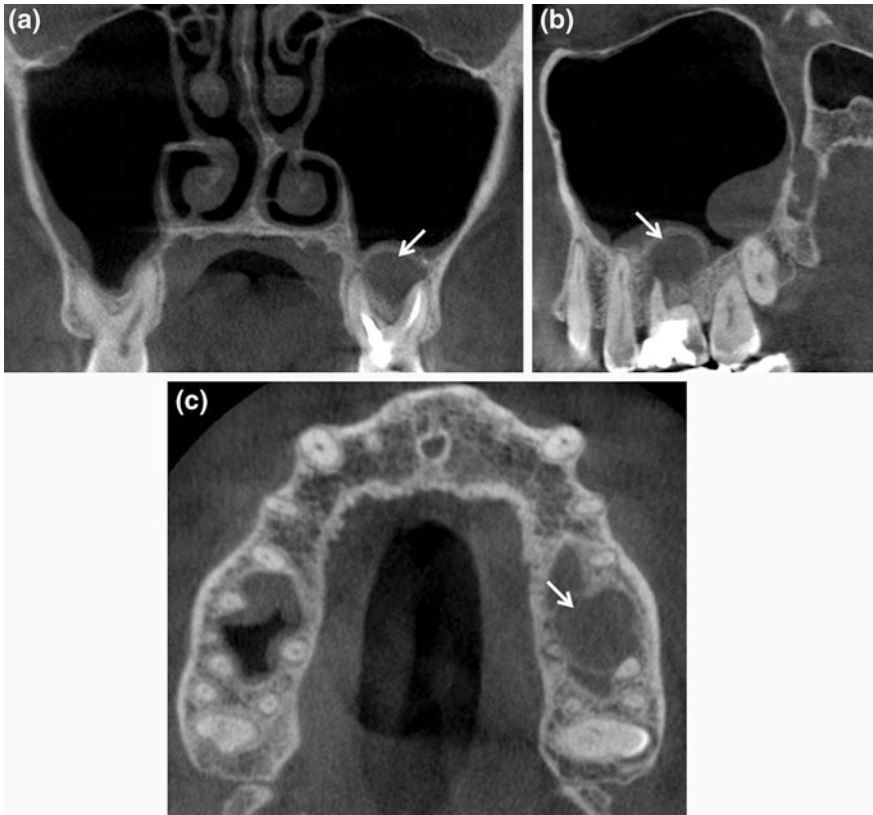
CBCT coronal (a), sagittal (b) and axial (c) scans demonstrating presence of odontogenic sinusitis in left paranasal sinus (*thin arrow*). Note the reactive bone formation within the sinus and the associated mucosal thickening
